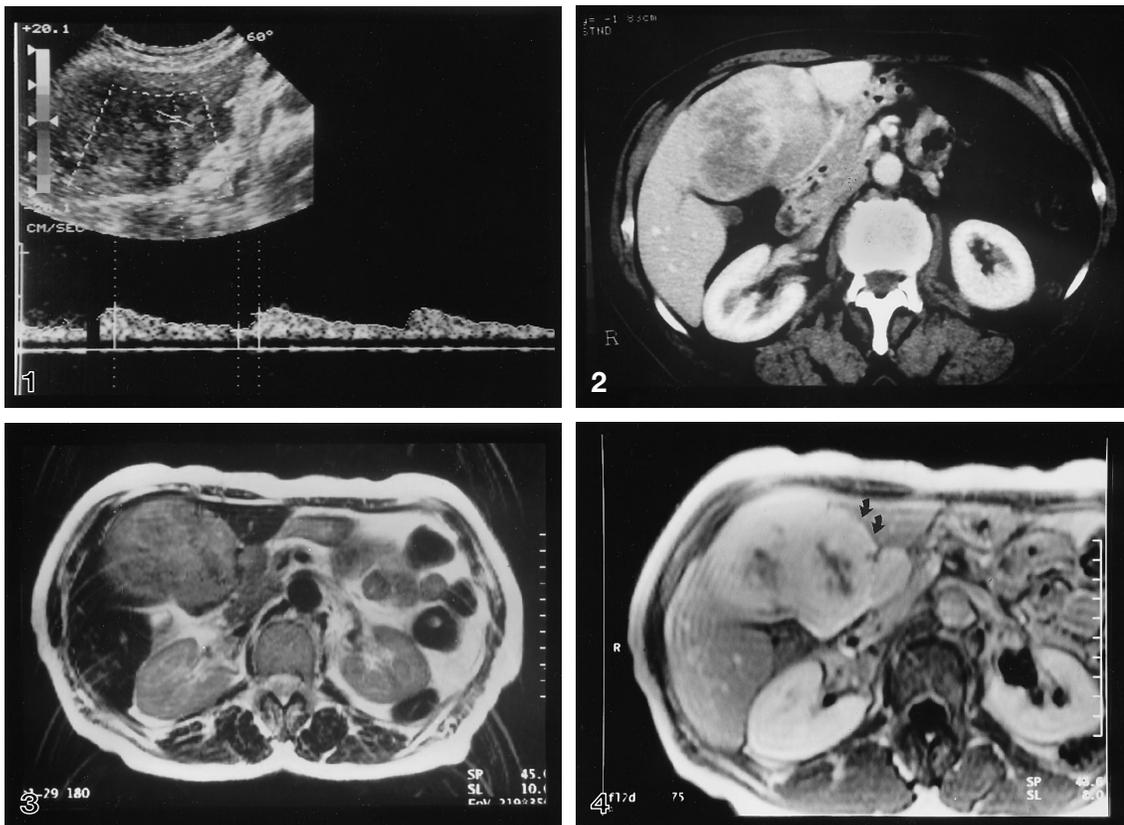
Color Doppler sonogram analysis demonstrates low-resistance arterial flow in and radial vessels within hypoechoic tumor of segment IV
